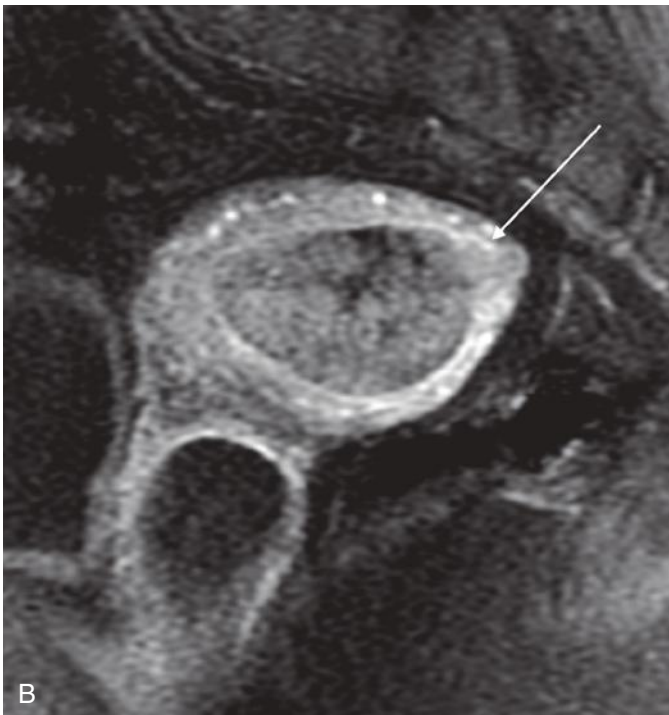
Stage IA endometrial cancer. Sagittal T2-weighted (A) and sagittal dynamic gadolinium-enhanced fat-saturated T1-weighted (B) images show a tumor filling the endometrial cavity with irregularity at the endometrial-myometrial interface posteriorly (*arrows*). Additional images were used to diagnose less than 50% myometrial invasion. Pathologic examination confirmed that the tumor invaded 4 mm into a 12-mm thick myometrium.
